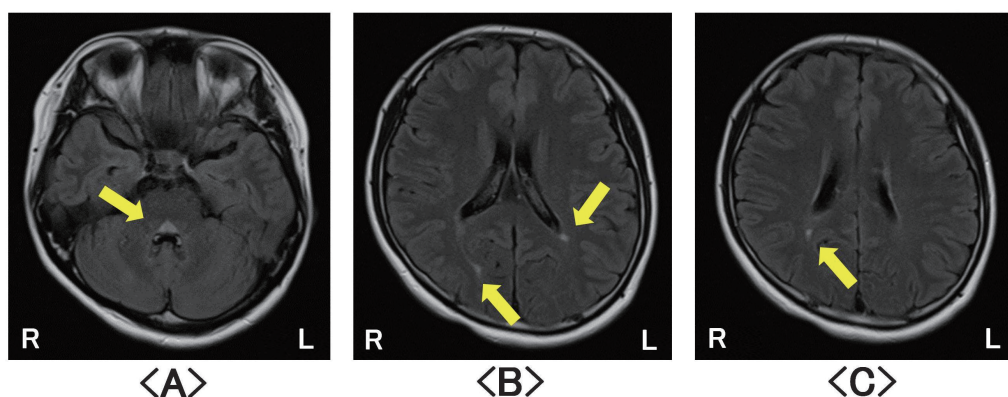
Magnetic resonance images obtained on the first day after hospital admission
